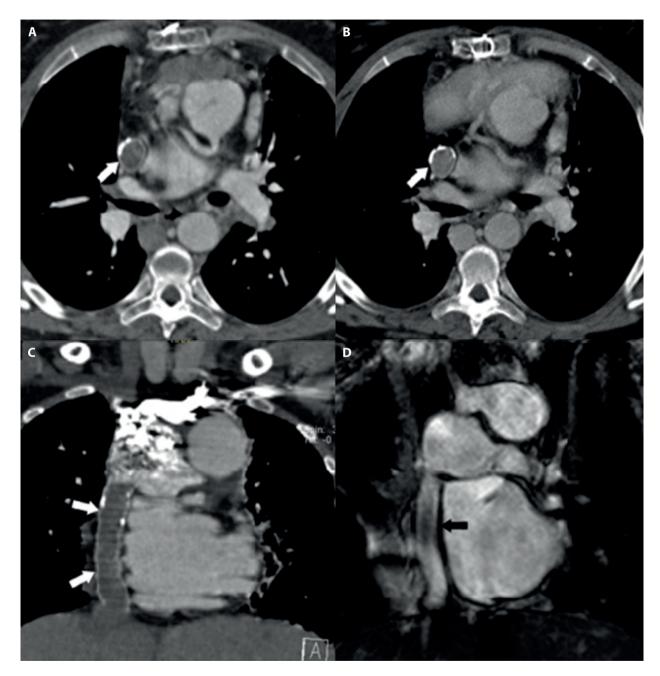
CT scans acquired during arterial (a,c) and late phase (b) did not show a clear opacization of the prosthesis (white arrows). Bright-blood coronal b-SSFP image (d) shows the presence of a signal void within the prosthesis (black arrow).
